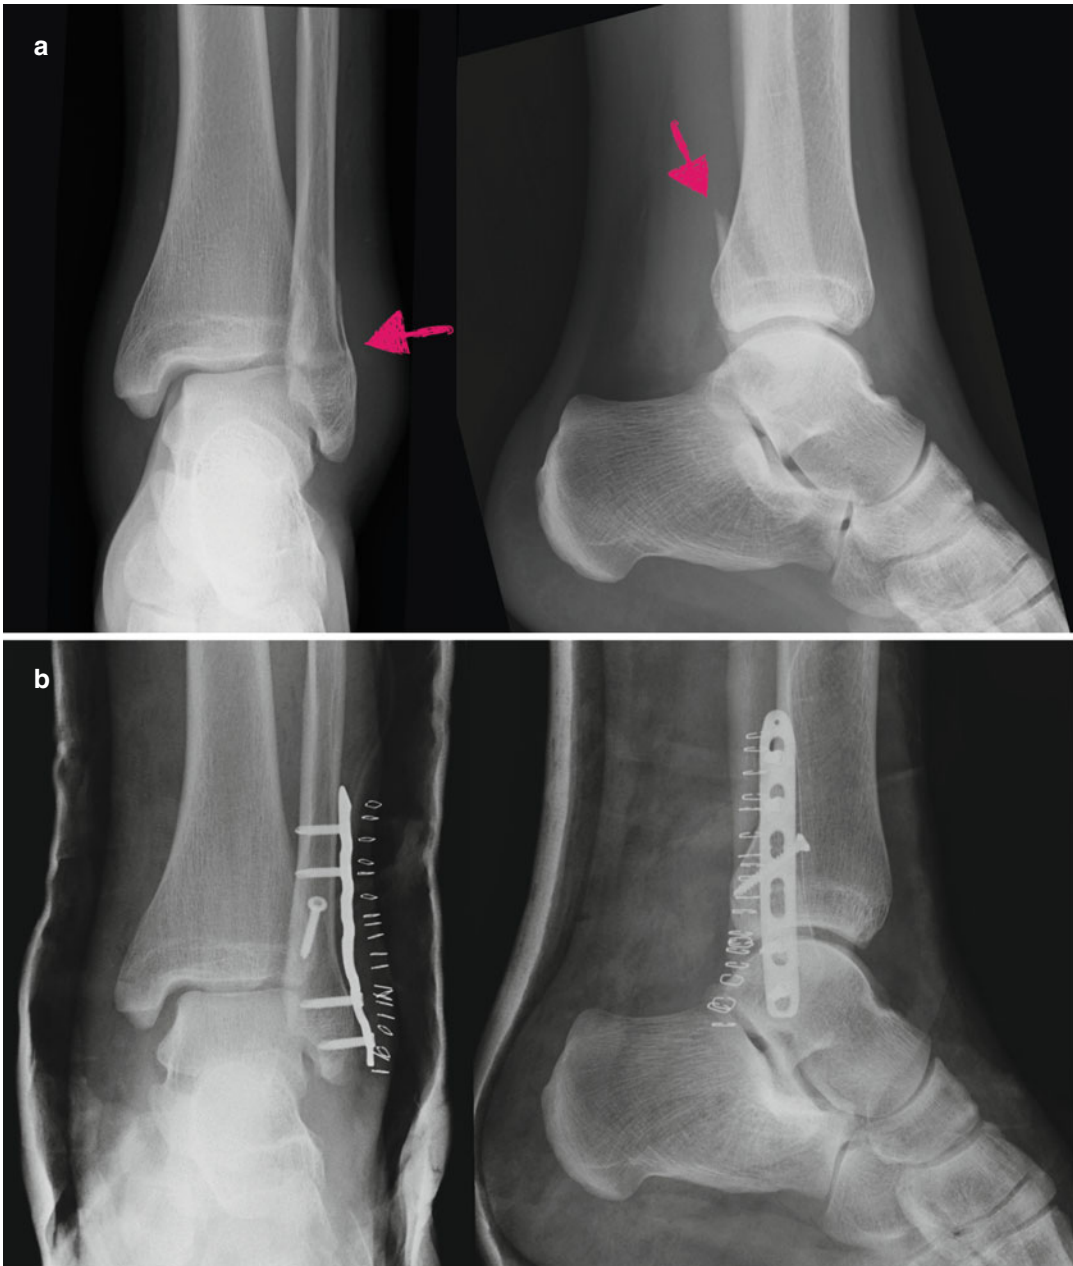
Foot strap injury: distal fracture of the fibula, diagnosis, and treatment. Radiographs: anteroposterior (a) and laterolateral (b) projections, showing fracture
